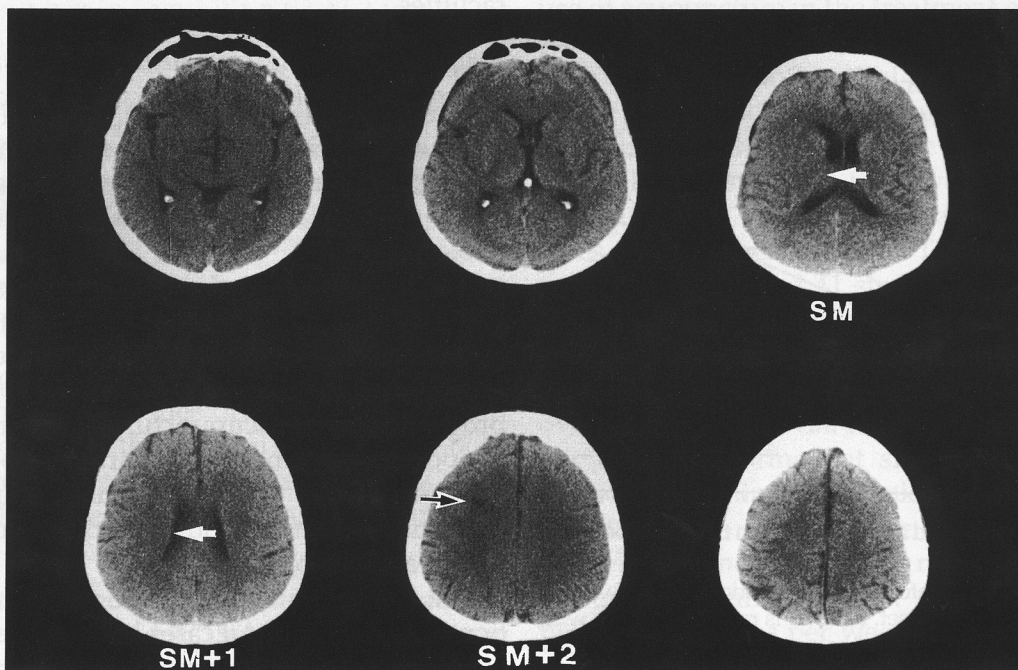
(bottom). CT scan for case KL; lesion is present in the subcortical, anterior white matter area, on slice SM + 2 (black and white arrow); the PVWM area on slices SM and SM + 1 is completely spared (white arrows). CT scan is 3 months poststroke. Source: Naeser MA, Alexander MP, Stiassny-Eder D, Lannin LN, Bachman D. Acupuncture in the Treatment of Hand Paresis in Chronic and Acute Stroke Patients-Improvement Observed in All Cases. *Clinical Rehabilitation* 1994b;8:127-41.
